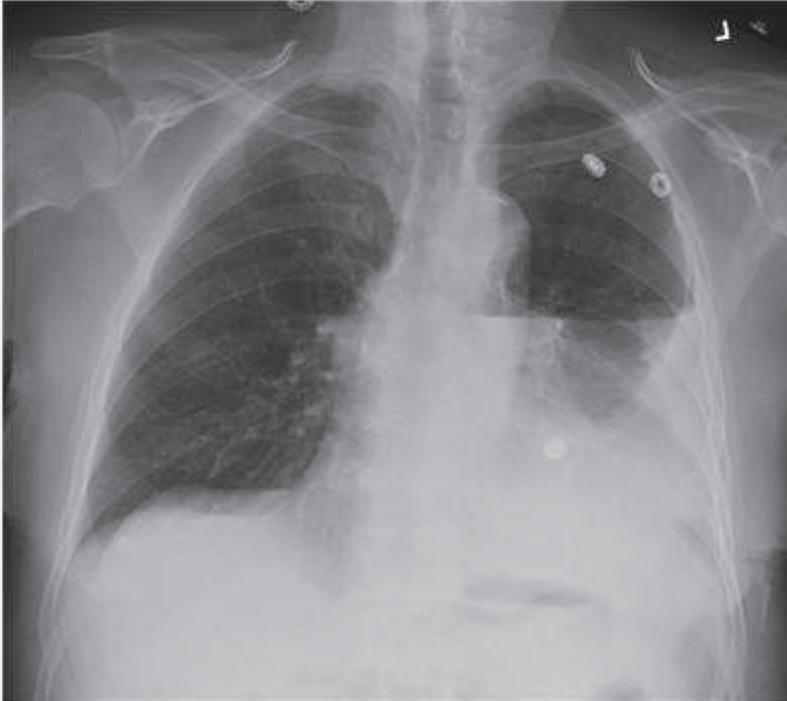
A Text: PA chest x-ray
